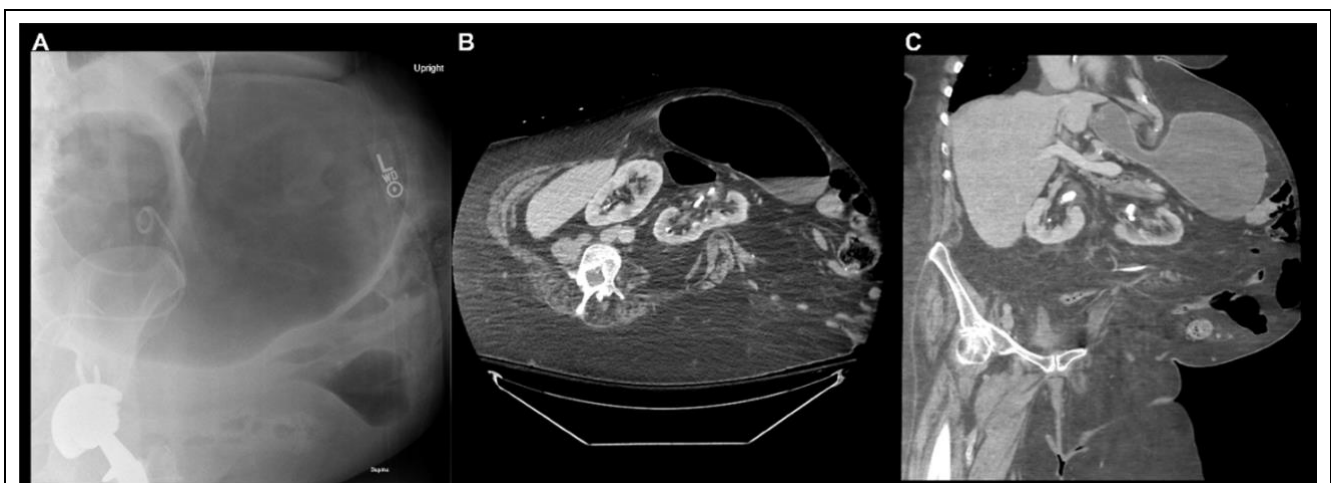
(A) Abdominal radiograph revealing marked gaseous distension overlying the left hemiabdomen. Axial (B) and coronal (C) views of a CT of the abdomen showing a complex ventral hernia with herniation of the stomach, small intestine, and large intestine.
